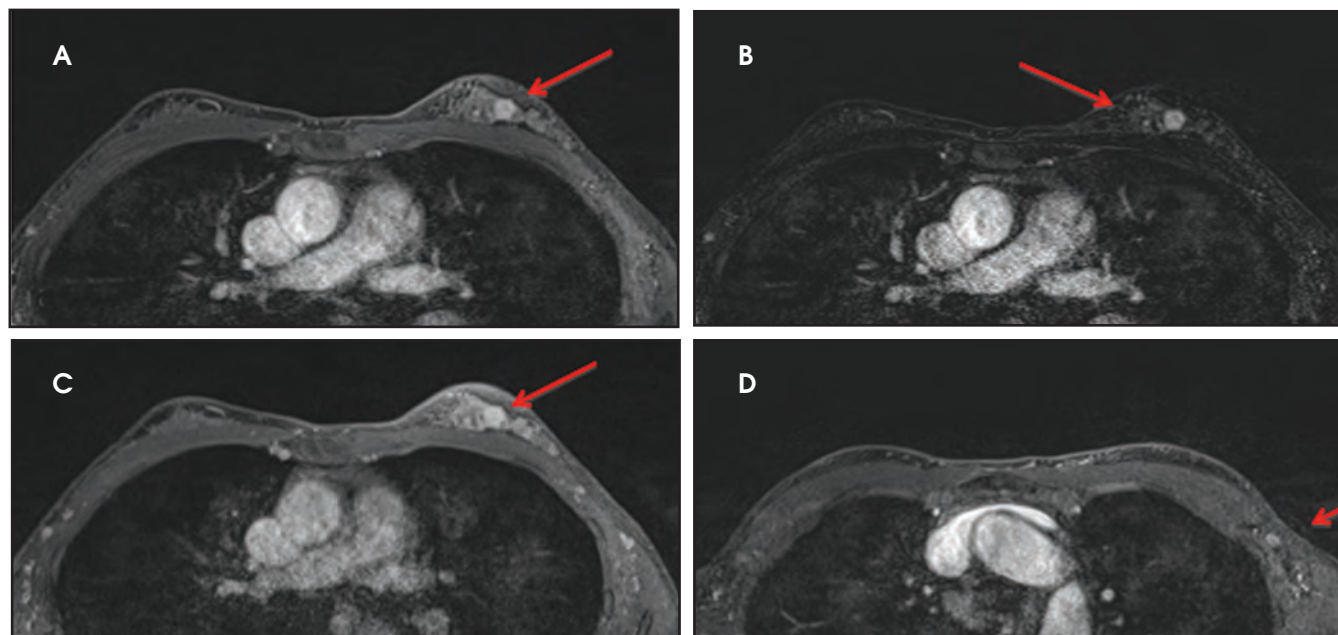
Bilateral breast MRI: Preoperative breast MRI is requested by the surgeon as the patient is high risk due to extremely dense breasts and atypical ductal hyperplasia on core needle biopsy. (A) Axial fat-suppressed T1W and (B) corresponding subtracted image of the dynamic series is shown at first time point obtained 30 sec after injection of gadolinium based contrast. (C) High resolution axial T1W fat-suppressed image of the same image is shown 180 sec after injection of contrast. (D) Axial T1W fat-suppressed image of the axillary region is shown at the first time point. The background parenchymal enhancement is markedly asymmetric, being minimal on the right and moderate on the left (B with arrow). A highly suspicious 1-cm spiculated enhancing mass is noted at 12 o'clock position in the left breast (A with arrow) with no associated enhancement of the pectoral muscle or chest wall to suggest invasion. Correlation with mammogram (Figures 5A and 5B) demonstrates that this mass is in the vicinity of a cluster of suspicious calcifications noted on mammography. The mass demonstrates initial rapid enhancement and subsequent plateau enhancement (A and C). One left axillary lymph node demonstrates a mildly thickened cortex (D with arrow). No abnormal enhancement of the right breast or additional focal abnormal enhancement of the left breast or right axillary or internal mammary chain adenopathy is noted. BIRADS Assessment Category 5: Highly suspicious for malignancy. Recommendation: Left breast and axillary ultrasound and imaging-guided biopsy of the highly suspicious left breast mass.
